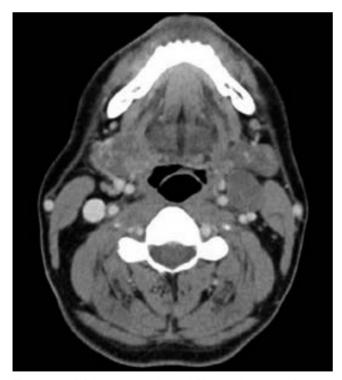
Axial contrast-enhanced CT scan demonstrating lymph node abscess in left parapharyngeal space. Note posterior displacement of internal jugular vein and medialization of carotid vessels. Mass effect and mucosal oedema cause subtle asymmetry of the airway at the level of the epiglottis.
